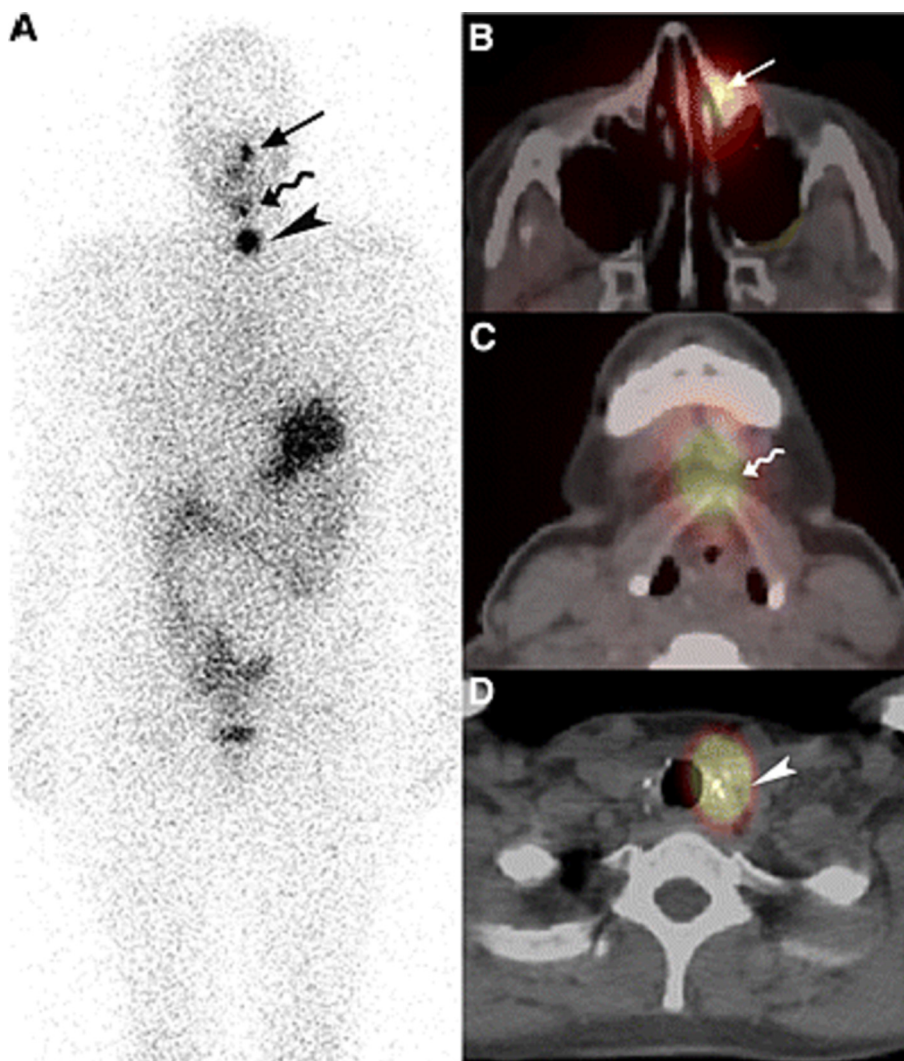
Image A: Planar whole body image indicates three centres of potential activity. Image B: SPECT/CT image indicates benign involvement of nasolacrimal duct; Image C: Indication of benign embryologic migration of thyroid. Image D: Indicates tumour that remnant post-surgery (Avram, 2012).
